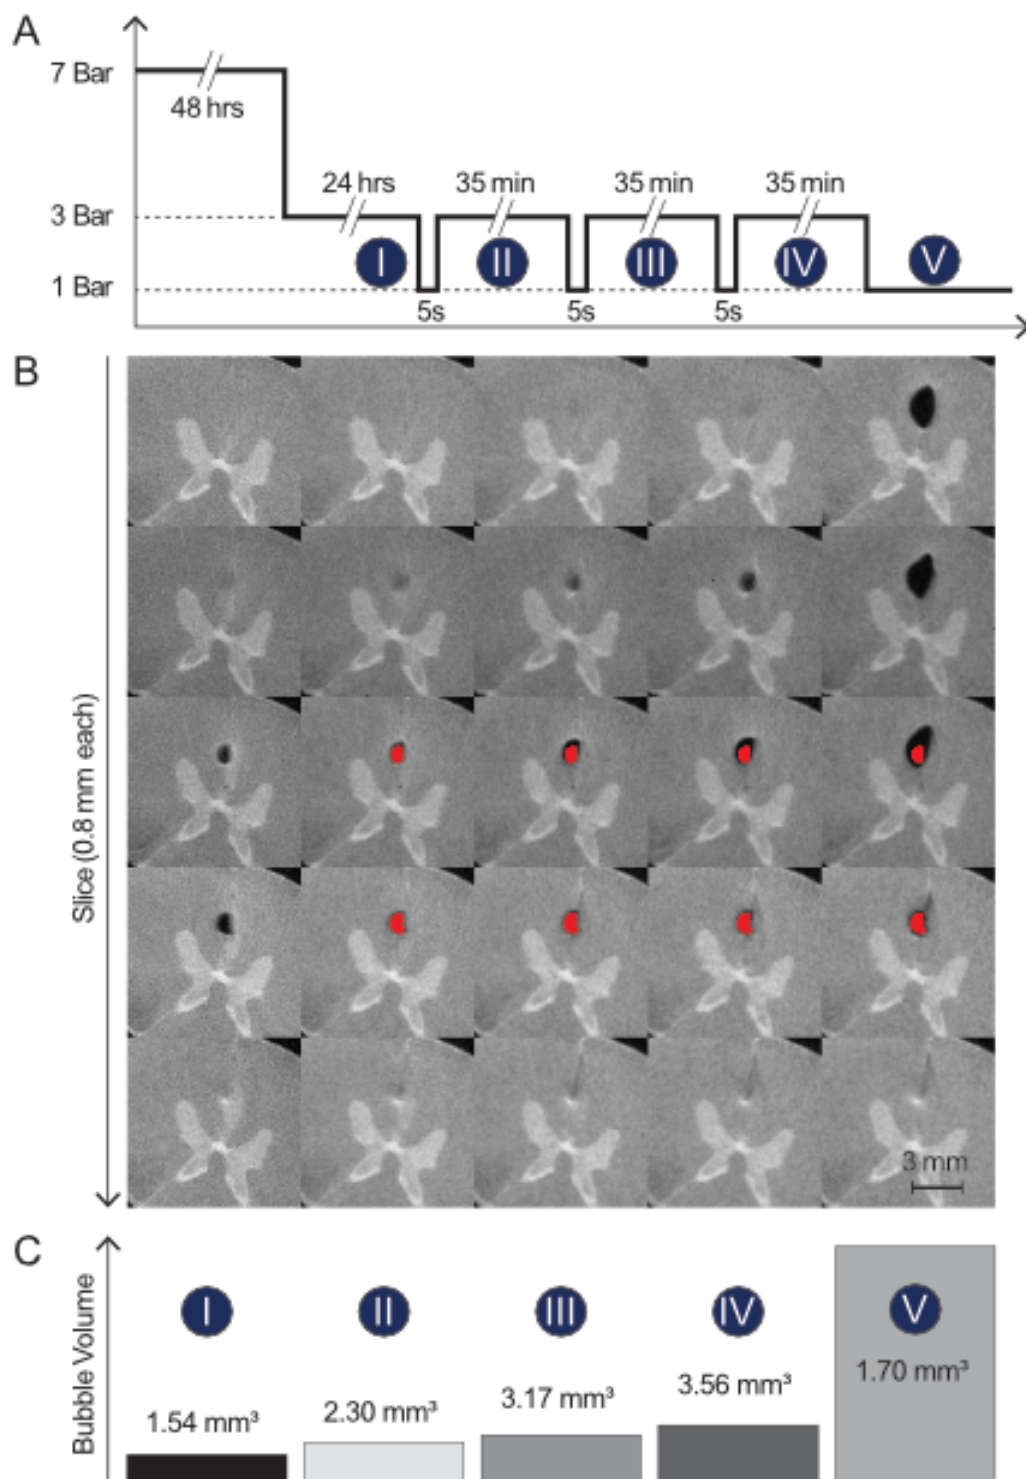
An example for one bubble growth is shown. (A) The pressure cycle is shown that is applied to all samples. Samples were imaged at points I, II, III, IV, and V. (B) Axial MRI scans show bubble growth for each pressure cycle. The leftmost frame indicates the equilibrated bubble and is overlaid in subsequent frames as a reference (red). (C) The bubble volume is quantified and shows a clear increase in volume for each pressure cycle.
